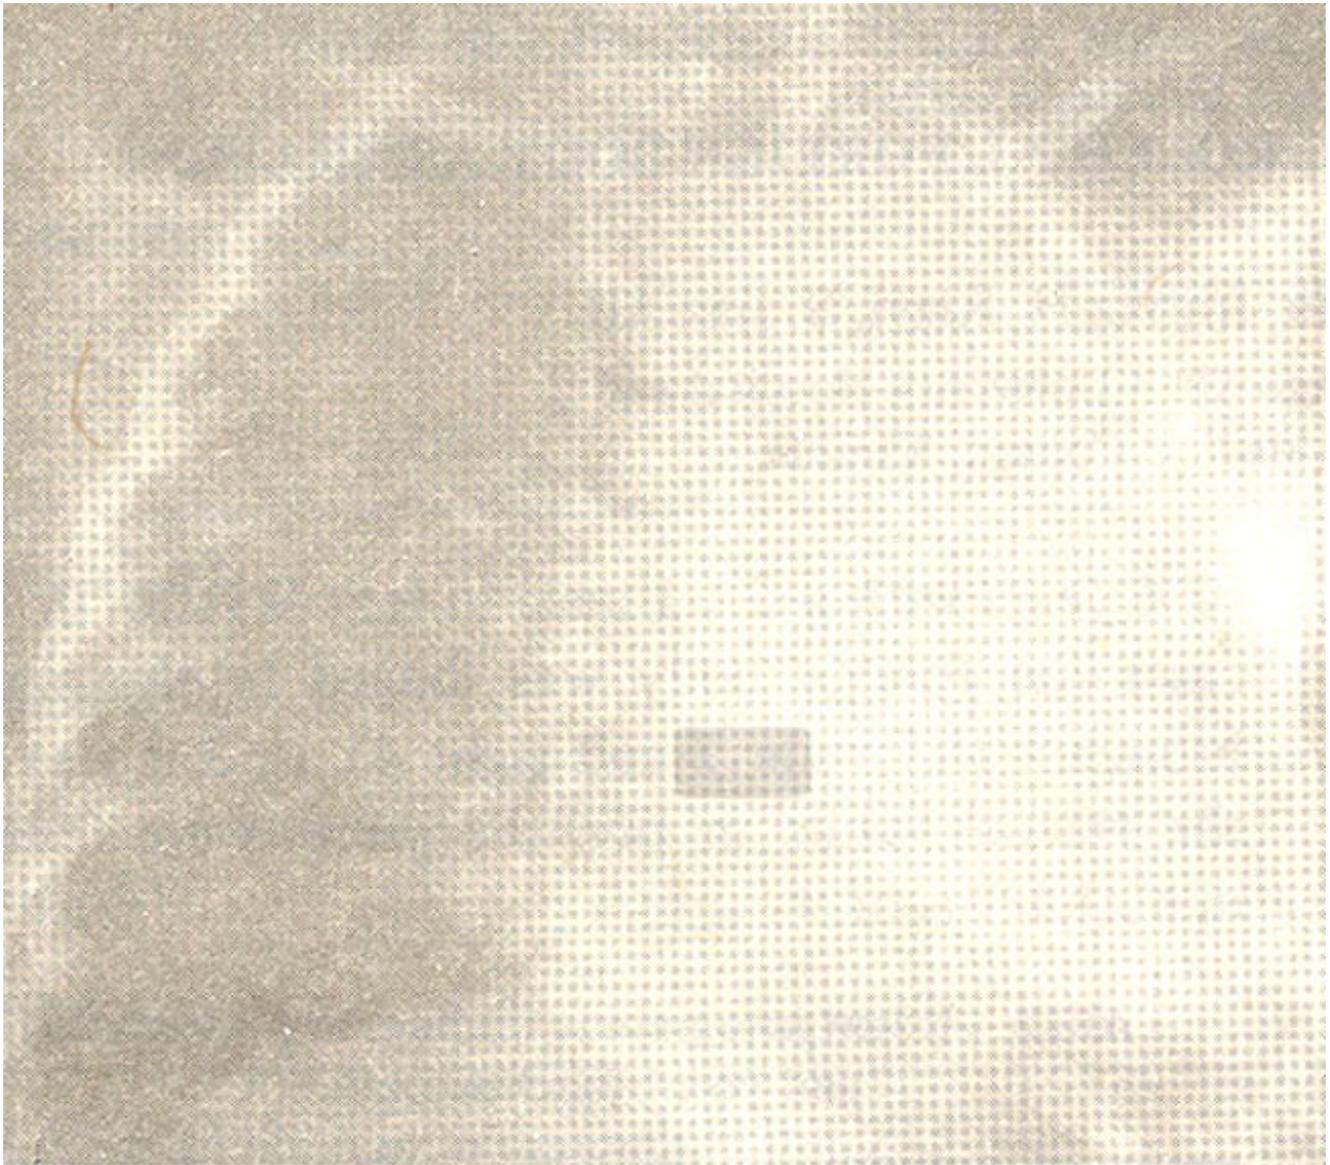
Chest radiograph showing complete collapse of left lung in a patient with foreign body in left main bronchus.
